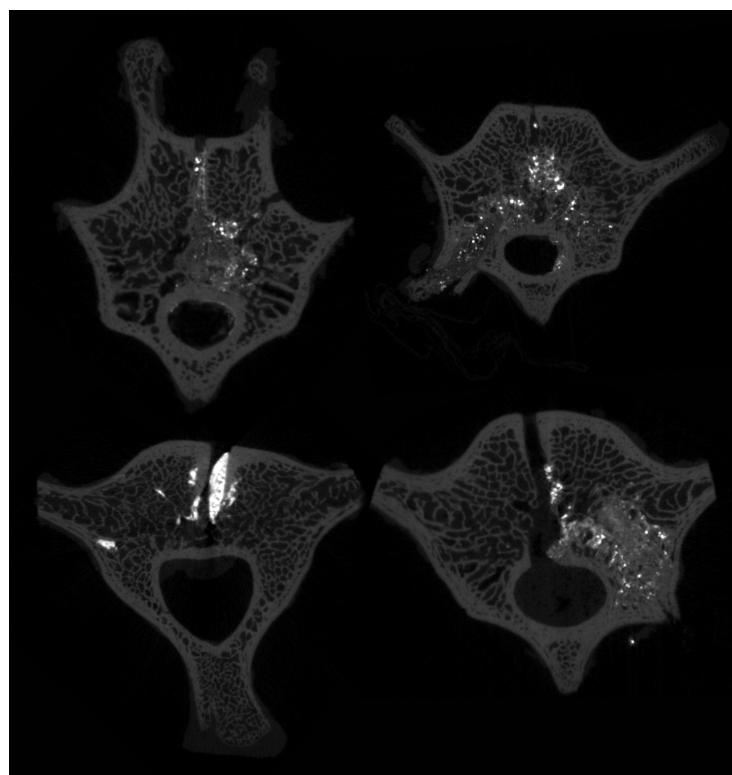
μ CT scans of four augmented vertebra using a steel rod to fill the spinal canal and blu-tac to cover the external vascular channels. Shows greatly reduced cement content within the spinal canal with less cement at the surface of vascular channels.
